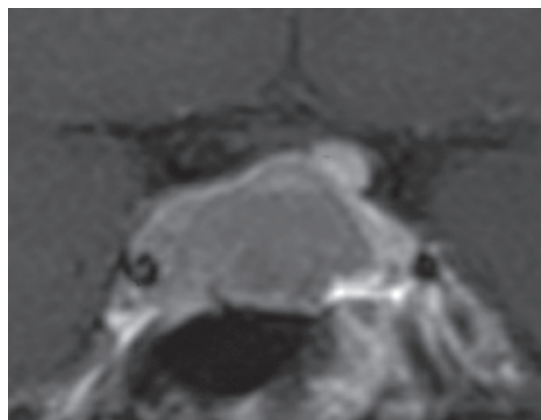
MRI revealed a pituitary macroadenoma with suprasellar extension. The normal gland was compressed to the left side of the sella turcica.
